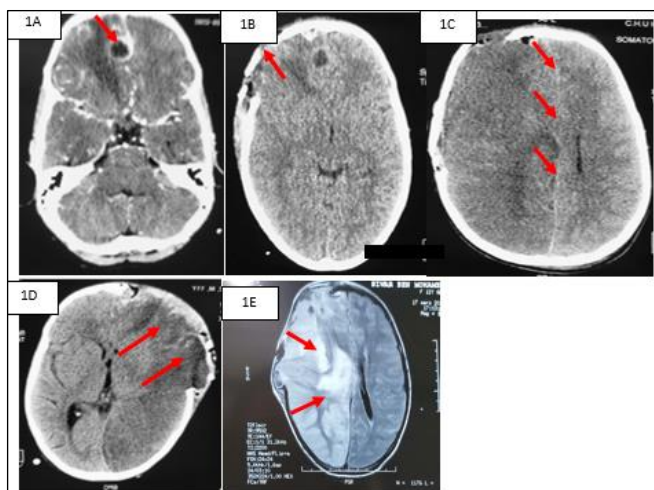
1A: Injected CT scan: parietal brain abscess. 1B: control brain CT scan after surgery. 1C: Control brain CT scan after neurological worsening: increase in cerebral edema, increased midline deviation by 10 mm. 1D: Control brain CT scan after the second surgery: flap enlargement and frontal lobectomy. 1E: MRI T2FLAIR: signal anomaly in the cortical zone and in the right frontoparietal white matter not systematized in FLAIR hyper signal with a restriction of the Apparent Diffusion Coefficient.
